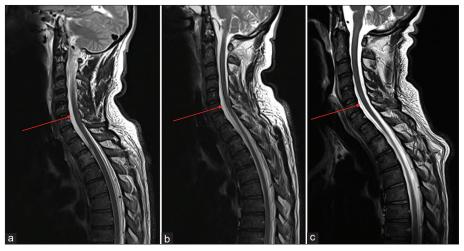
Serial magnetic resonance imaging spines demonstrating steadily reducing epidural fluid collections (red arrows) on (a) day 1 postoperative (b) day 1 post first blood patch, and (c) day 1 post repeat blood patch.
